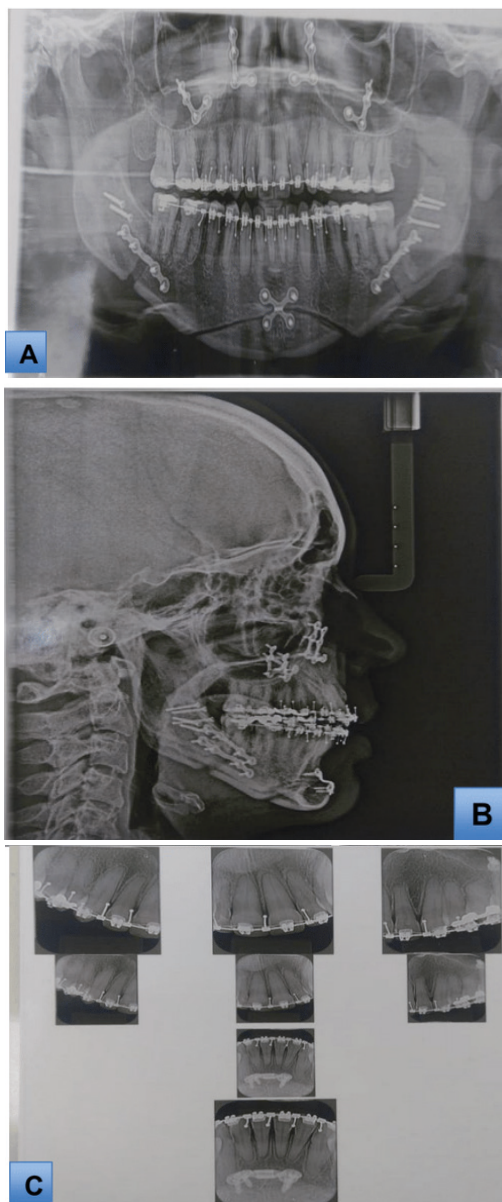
A/B/C Panoramic radiograph after surgery
